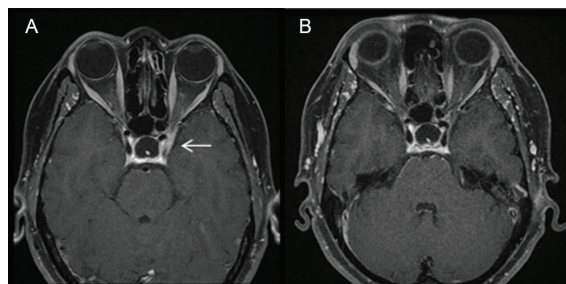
A) Axial T1 post gadolinium MRI showing enhancing soft tissue thickening at left side cavernous sinus with encasement cavernous portion of the left carotid artery. B) Axial T1 post gadolinium MRI after prednisolone treatment, 10 month after initial MRI showed no abnormal soft tissue thickening.
